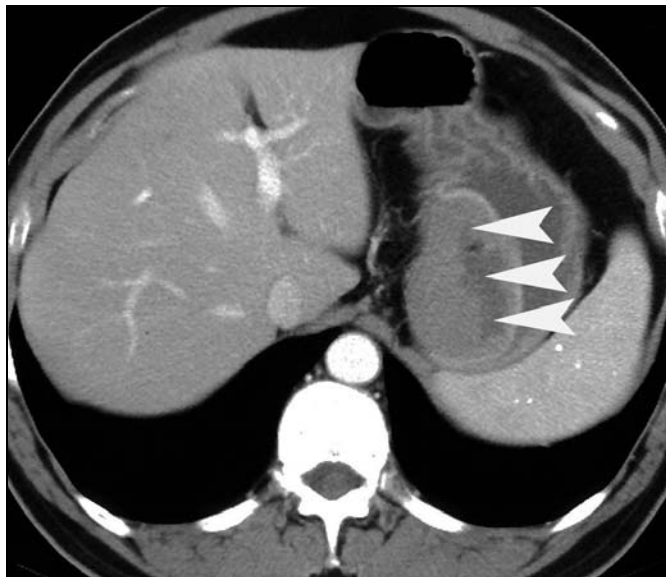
54-year-old man with gastric gastrointestinal stromal tumor. Axial contrast-enhanced CT scan of upper abdomen shows area of crescent-shaped necrosis (arrowheads) in tumor, "Toricelli-Bernoulli" sign.
